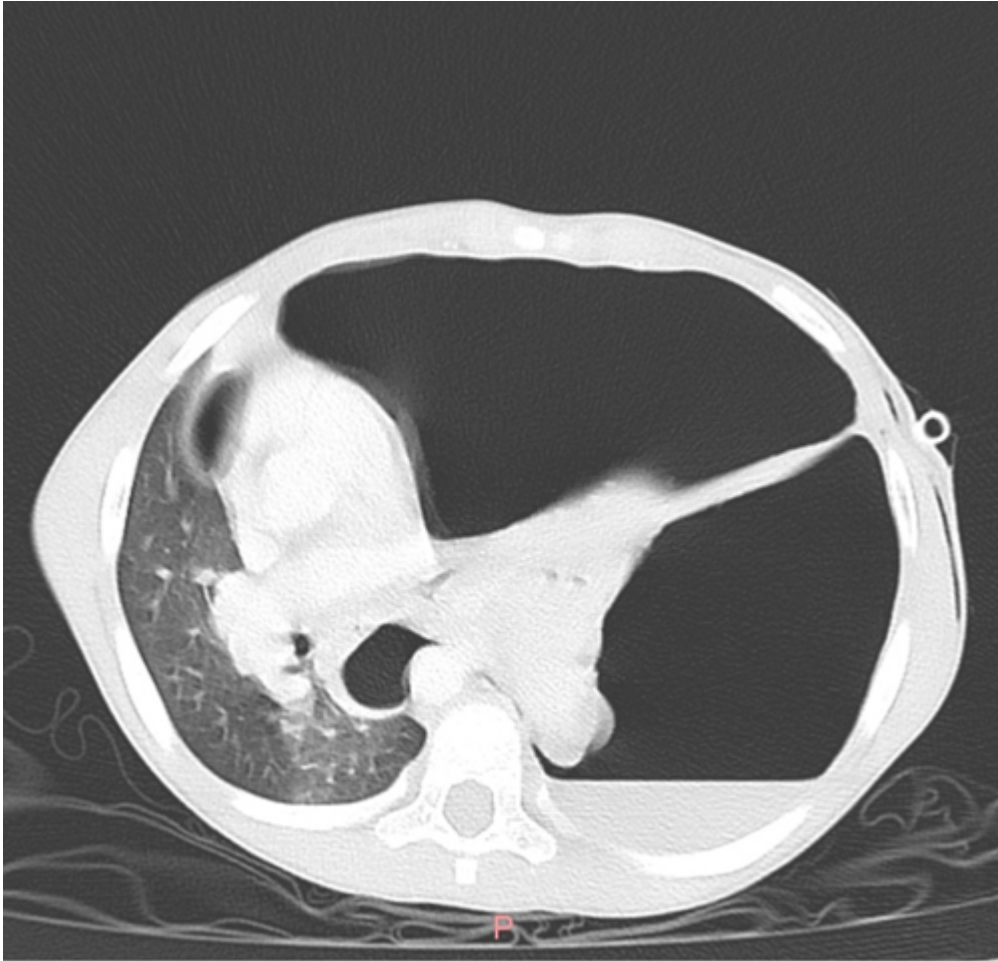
What abnormalities are seen on this CT? [↩](#)
